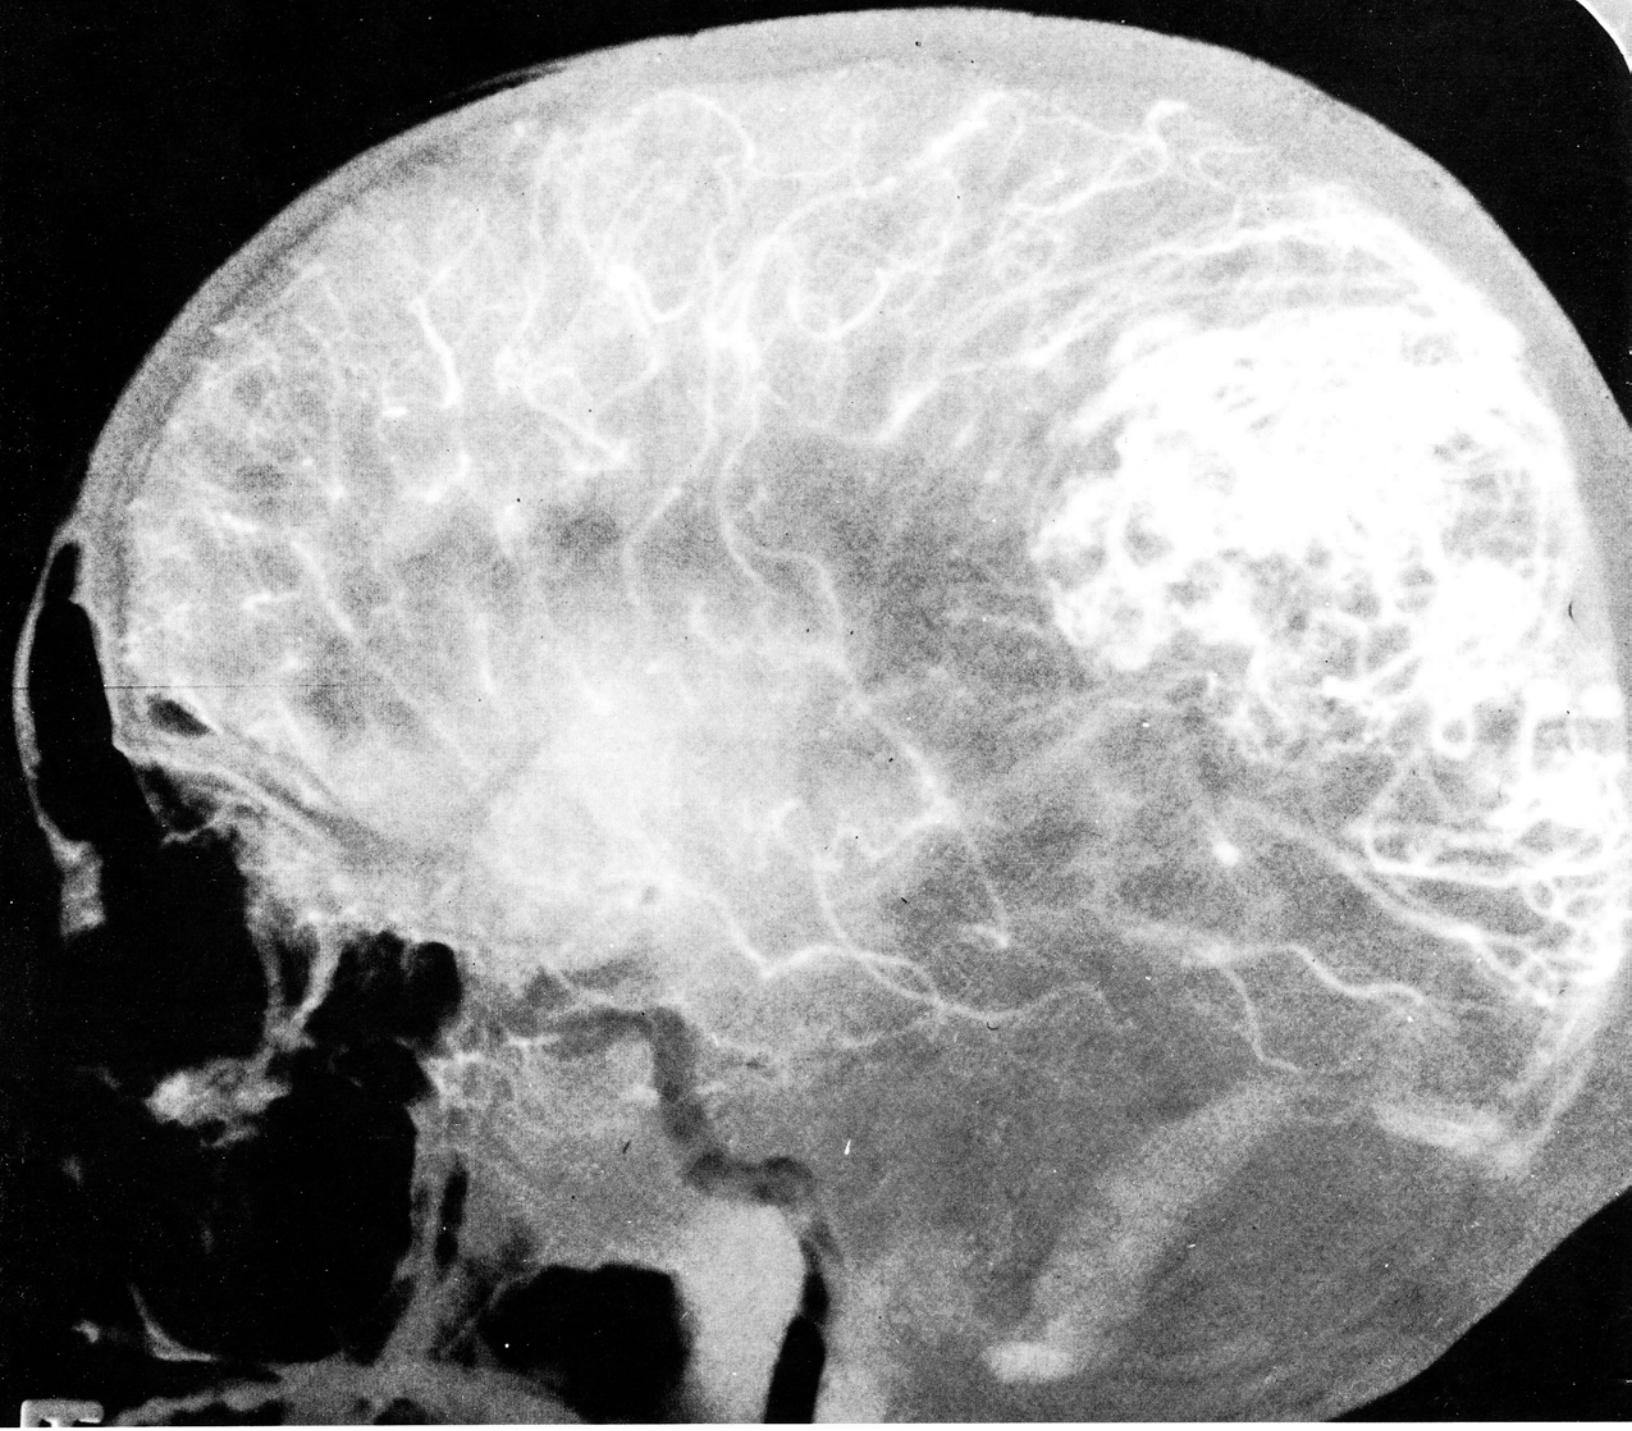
Subtraction roentgenogram showing dilated vessels in parietal region.
